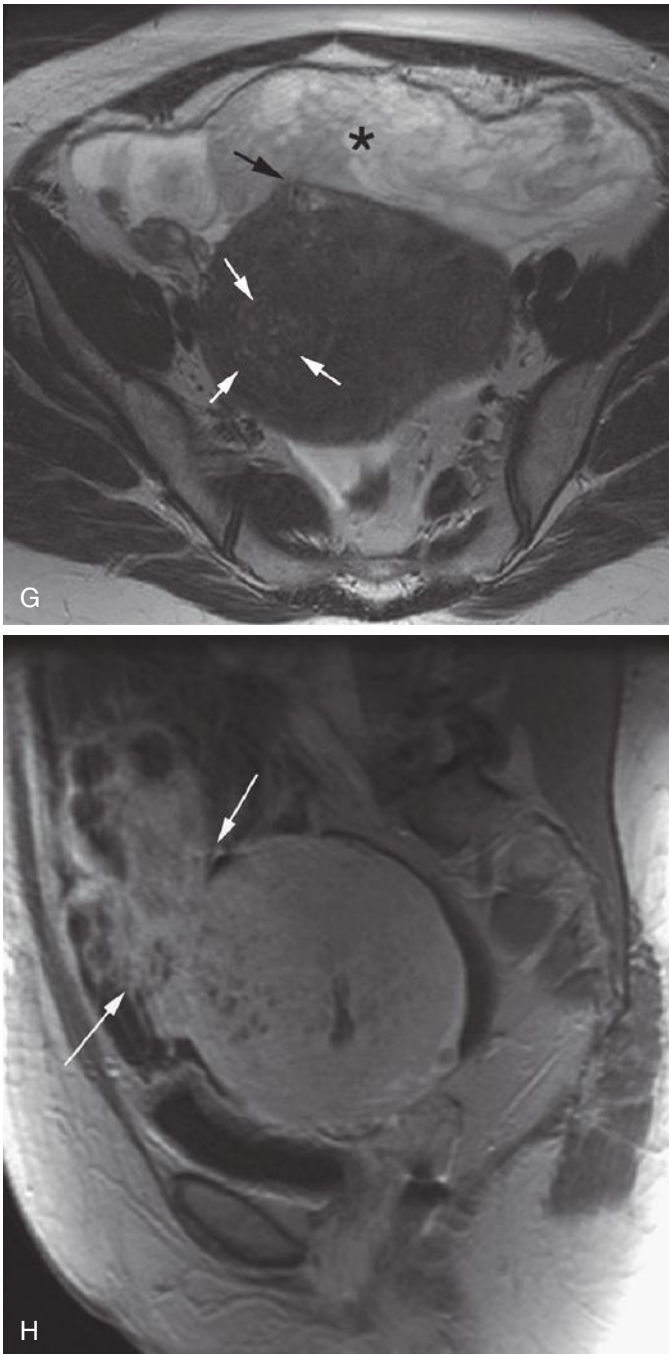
cont'd G, Axial T2 weighted MRI image better demonstrates the extent of the adenomyosis (diffuse low signal intensity of the myometrium) as well as the more focal adenomyoma (*white arrows*) with numerous small hyperintense foci. A small subtle area of serosal breakthrough is noted (*black arrow*), which represents “expelling” of the adenomyoma depicted as a large high T2W signal heterogeneous mass noted anteriorly (*asterisk*). H, Sagittal postcontrast T1W image demonstrates tumor extending from the uterine wall through the serosal surface into the anterior pelvis (*arrows*). The final pathologic image demonstrated endometrial stromal sarcoma with heterogeneous differentiation, FIGO stage III (International Federation of Gynecology and Obstetrics).
